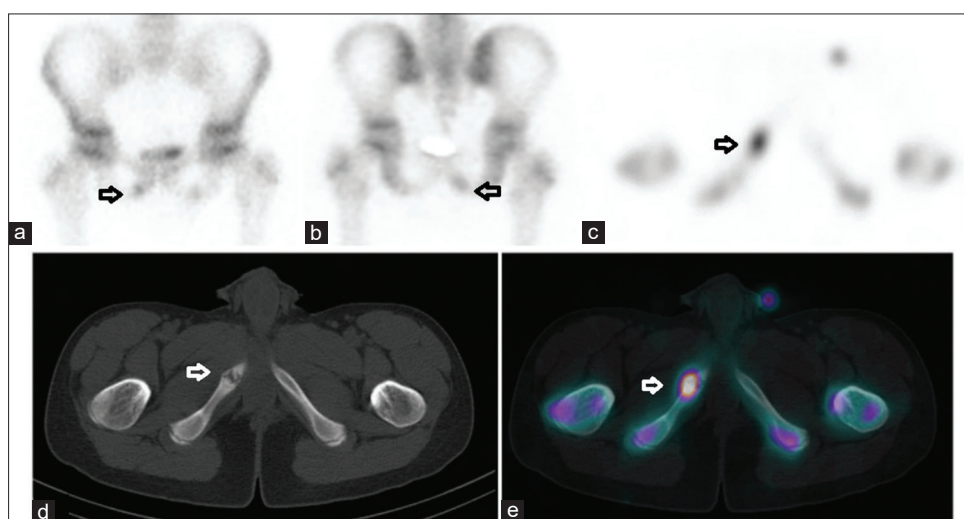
Bone scan ^{99m}Tc-MDP (anterior, posterior and axial) with single-photon emission computed tomography/computed tomography. (a-e) Increased uptake area in lower ischiopubic branch which in fusion images confirm the site of the ischiopubic synchondrosis
